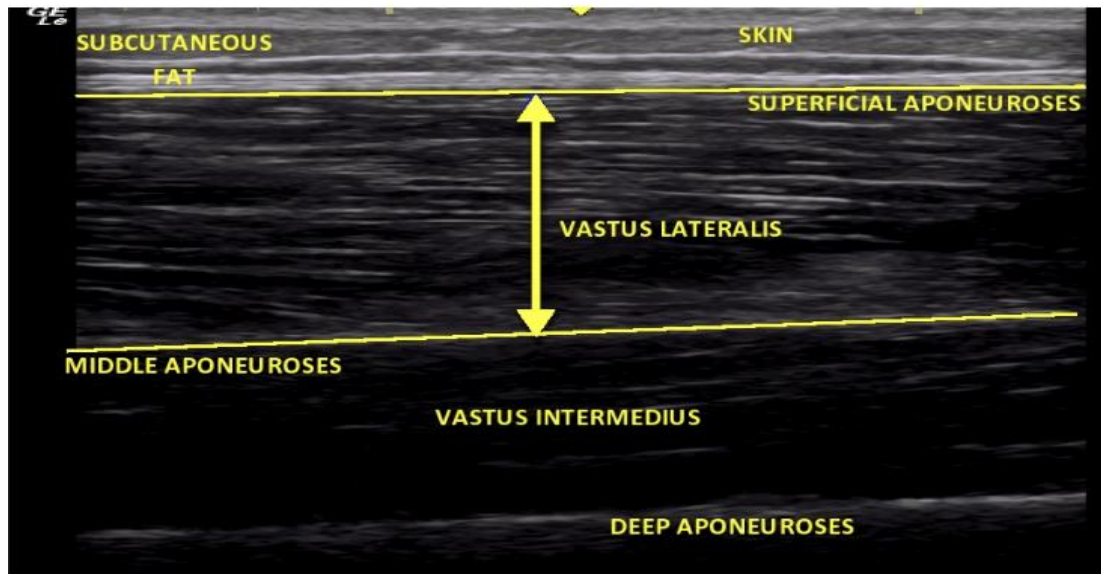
Picture showing the measurement of muscle thickness using an ultrasound.
